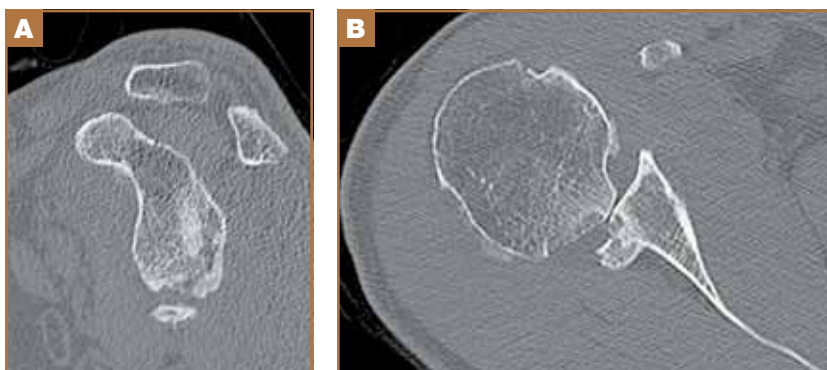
Preoperative CT images including sagittal (A) and axial (B) views demonstrating a reverse bony-Bankart and a reverse Hill-Sachs lesion; the humeral head was posteriorly subluxed with less than 50% articulating with the glenoid surface.
